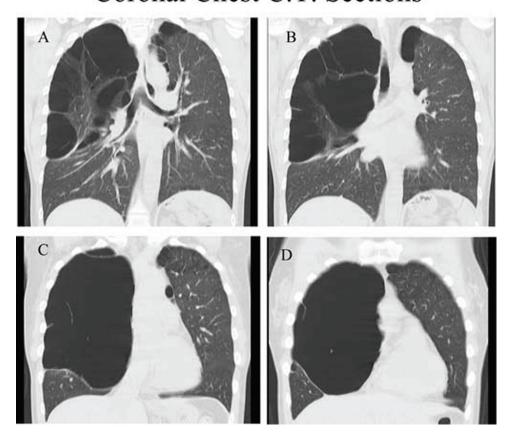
Coronal chest CT sections. (A) Smaller cycts posteriorly (B) Larger cysts in mid-lateral plane (C) Apparent cyst coalescence (D) Giant cyst diameter 19 cm.
